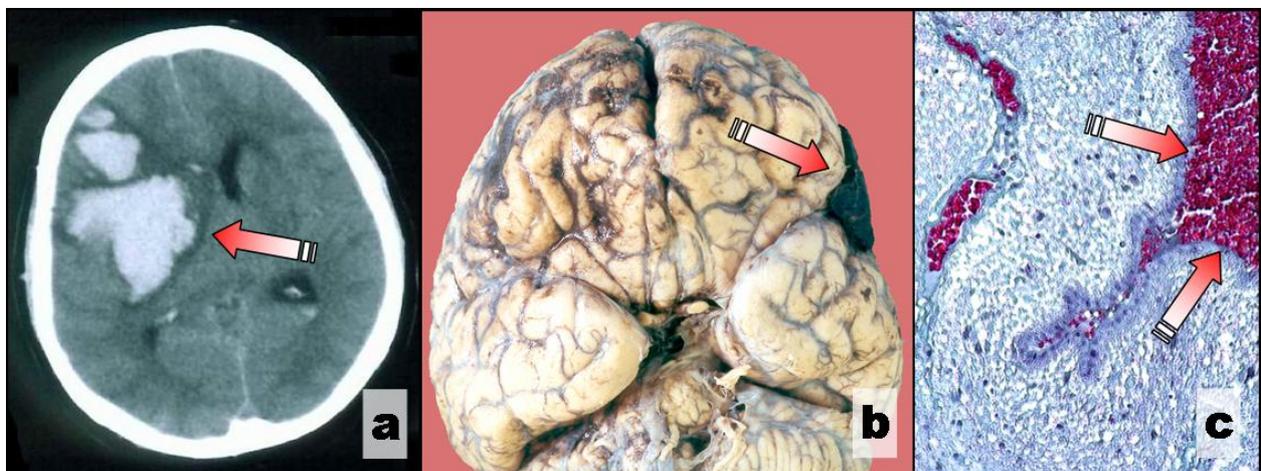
Left side extended frontal-parietal hematoma: (a) CT aspect; (b) Necropsy gross aspect; (c) Hemorrhage extension in the subarachnoid space.
